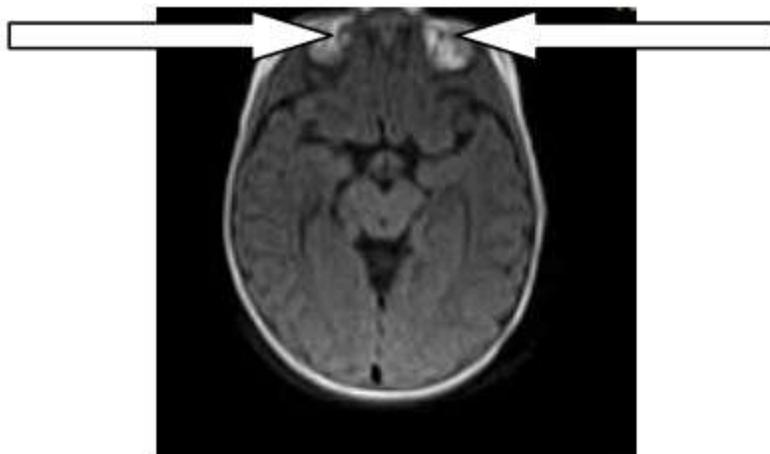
Axial T1-W MR image shows absent globes bilaterally with small amount of amorphous intra-orbital soft tissue and reduced orbital size(arrows). Brain is normal.
